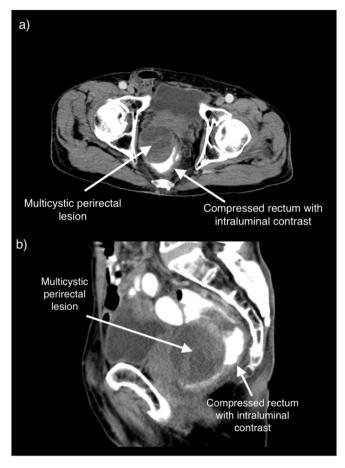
(a) Axial and (b) Sagittal view on CT scan showed external compression of low rectum by a large multi-cystic perirectal lesion.
